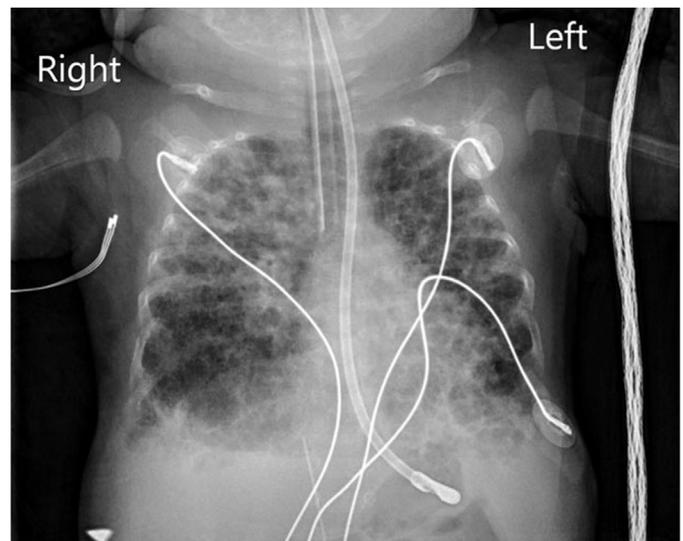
anteroposterior supine radiograph obtained portably demonstrates mild bilateral pulmonary hyperexpansion with coarse lung markings. Patchy parenchymal opacities are interspersed with areas of hyperlucency. The patient is intubated, with the tip of the endotracheal tube just above the carina.
